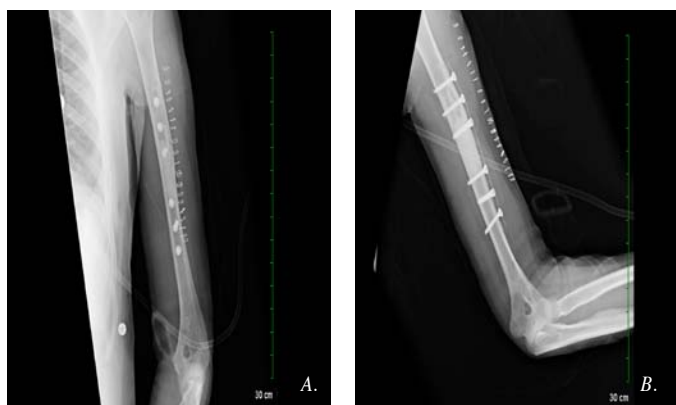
Anterior to posterior (A) and lateral (B) post operative plane film radiographs of a humerus treated with a CarboFix™ CF-PEEK larger fragment plate. The large fragment plate was used to prophylactically stabilize the humerus after an open bone biopsy at the diaphysis of the humerus. The void created by the lesion's removal is filled with radio-opaque bone cement.
